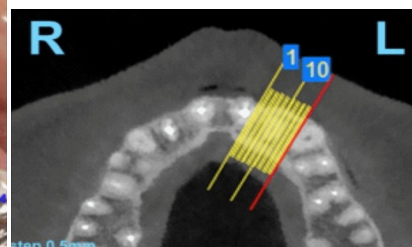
Planes of exposure in CBCT scans for tooth 22 (axial view).
